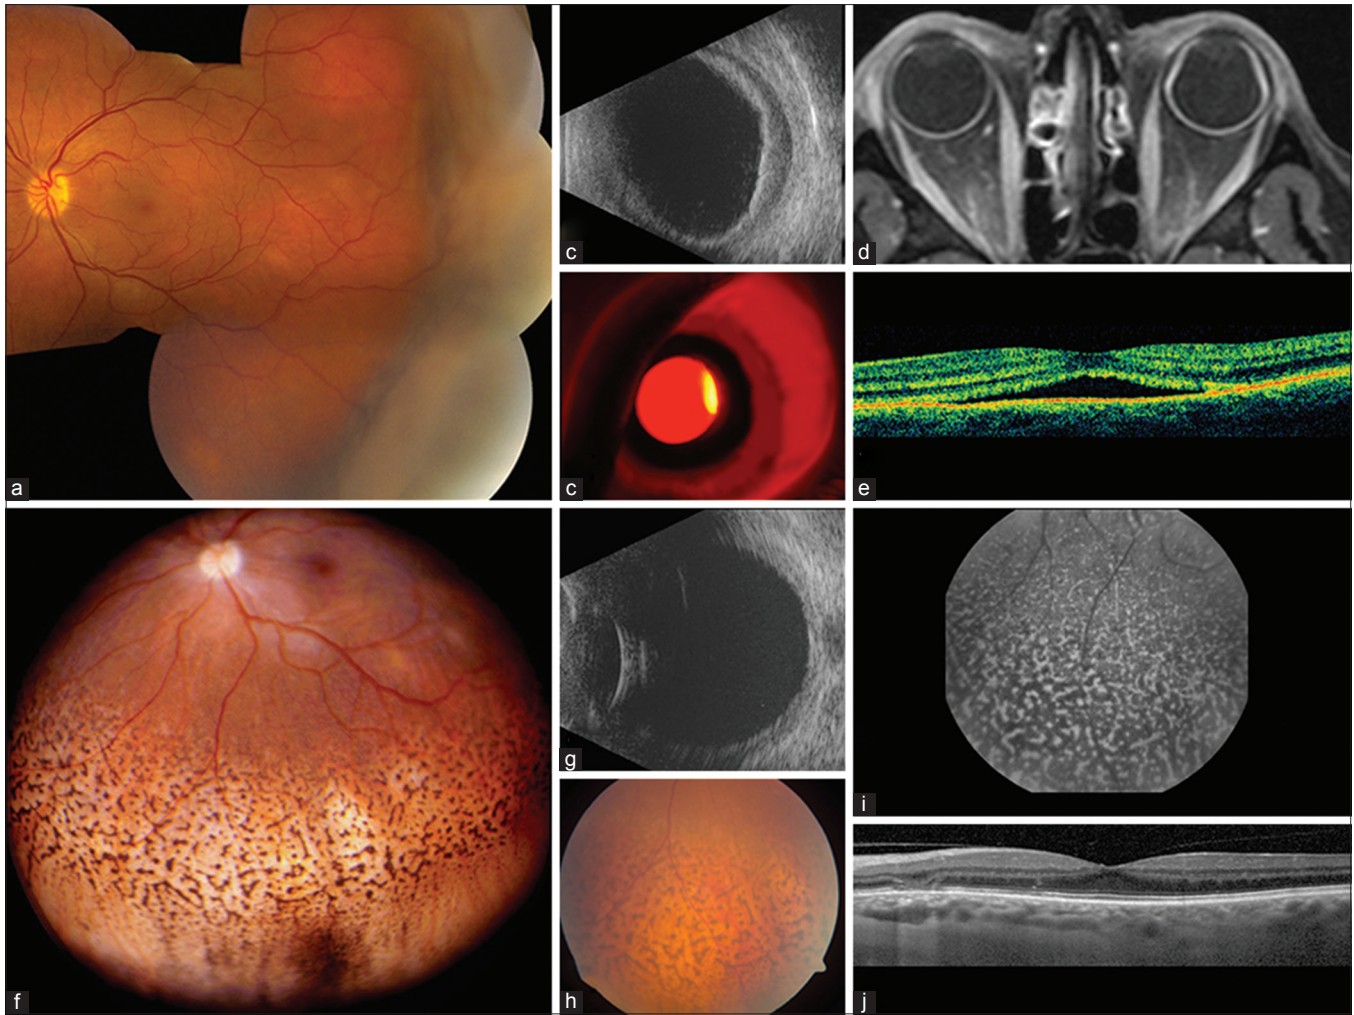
(a) Idiopathic uveal effusion, documented on (b) ultrasonography and demonstrating (c) no transillumination shadow. (d) Magnetic resonance imaging (T1) with gadolinium showing peripheral ciliochoroidal detachment and (e) optical coherence tomography confirmed subfoveal fluid. Following oral and periocular corticosteroids, there was (f) effusion resolution with retinal pigment epithelial mottling, (g) ultrasonographic flat retina, lipofuscin deposition (h) clinically and (i) on autofluorescence, (j) fluid resolution on optical coherence tomography, and final visual acuity of 20/40
